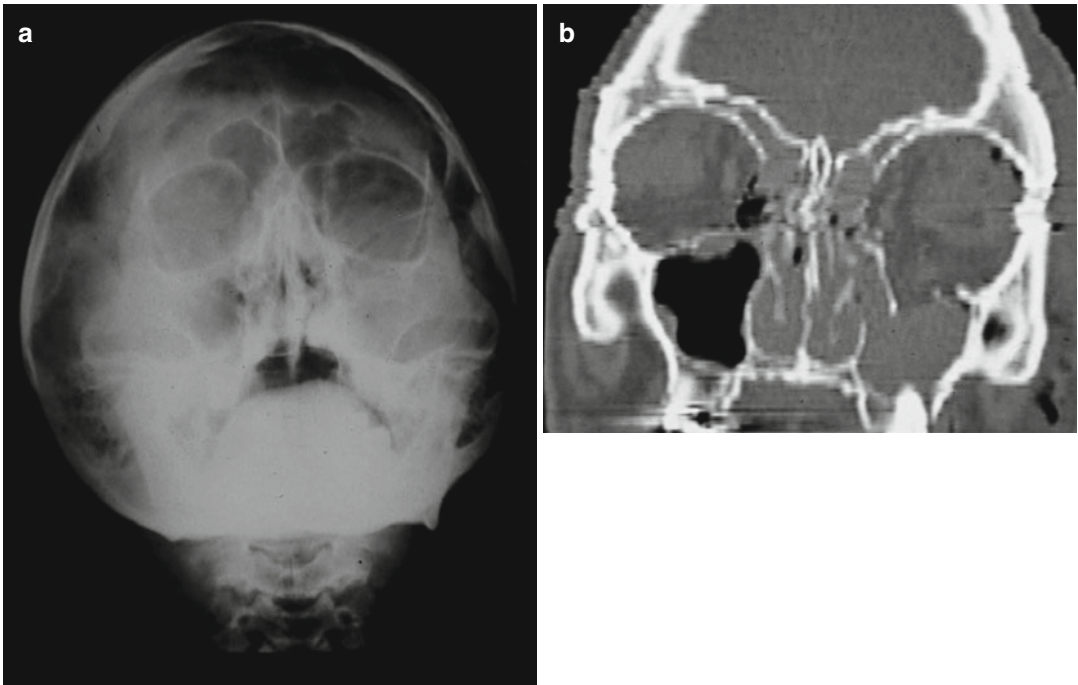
(a) Plain radiogram without abnormalities. (b) CT image on the right: door wing-like orbital floor fracture (diplopia)
